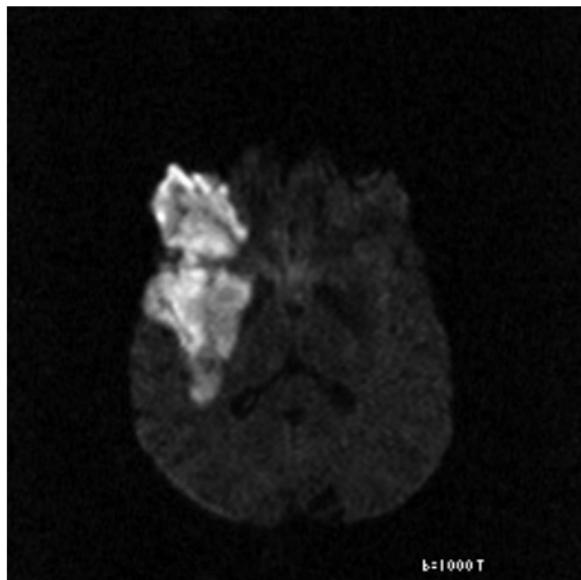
Acute right MCA territory infarct. (a) Non-enhanced CT; (b) T2 axial MRI (c) DWI; and (d) ADC map. (a): Subtle low attenuation in the right inferior frontal gyrus, frontal operculum, insular cortex, and putamen (white arrows) consistent with acute ischaemia. (b) T2 sequence shows gyral expansion, with effacement of local CSF spaces and abnormal signal in the corresponding area.
